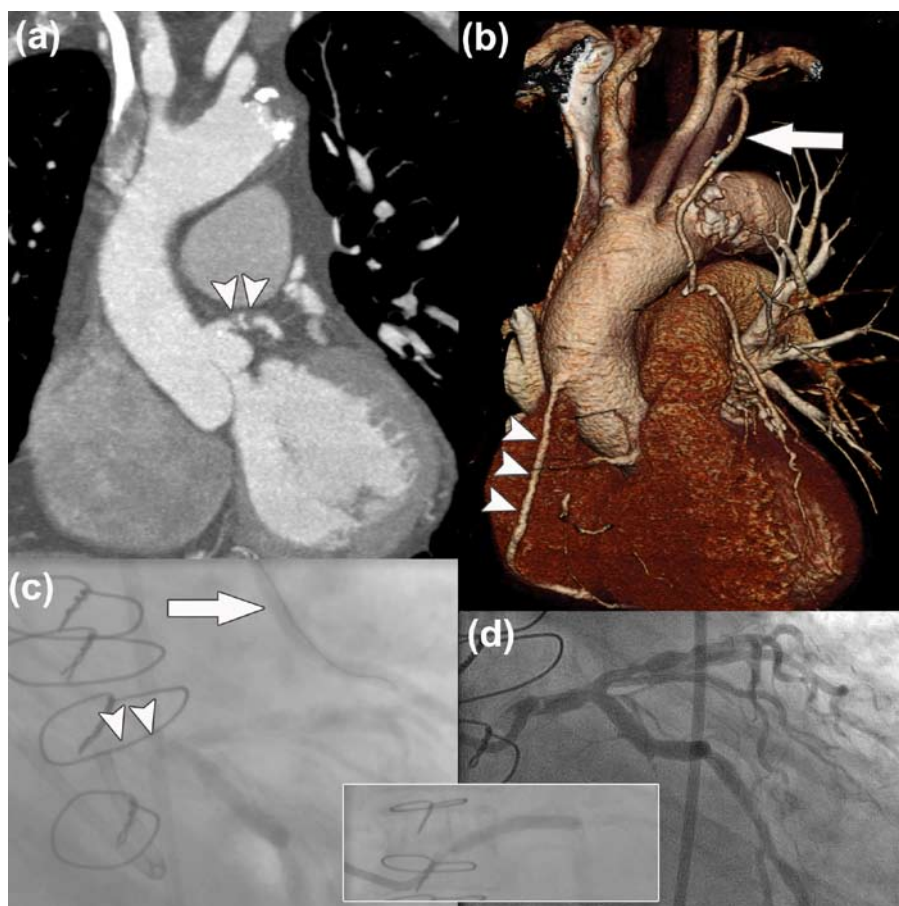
Patient with recurrent angina after previous coronary bypass graft surgery, including a venous graft to the right coronary artery (RCA) and left internal mammary artery (LIMA) to the left anterior descending coronary artery. At initial invasive catheterization the origin of the left coronary artery appeared occluded. (a) Cardiac CT scan, coronal view, indeed showing a short occlusion (arrowheads) of the left main stem. (b) Three-dimensional reconstruction of the heart showing the patent LIMA (arrow) and venous graft to the RCA (arrowheads). (c) Contrast injection after wiring of the LIMA (arrow) results in opacification of the native coronary artery up to the distal part of the left main stem. (d) Six-month angiographic result after successful PCI (inset) of the left main stem.
